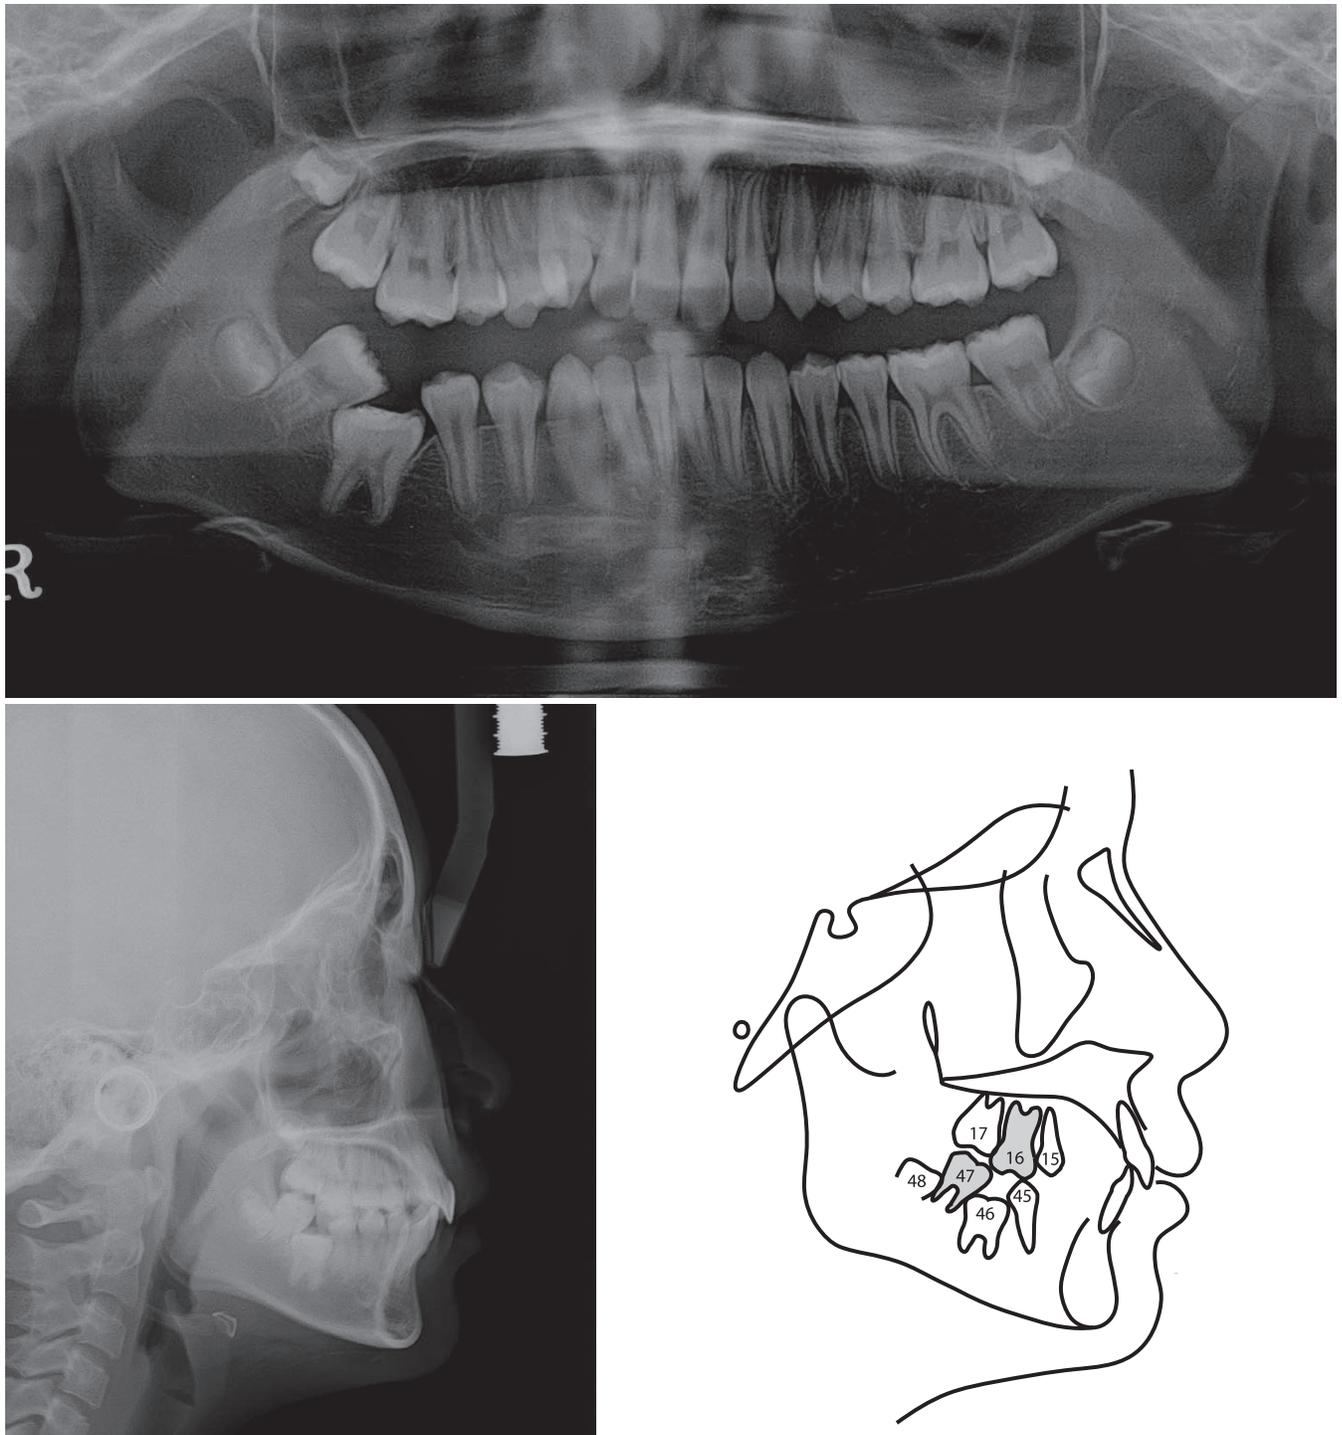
Pretreatment panoramic and lateral cephalometric radiographs and tracing.
